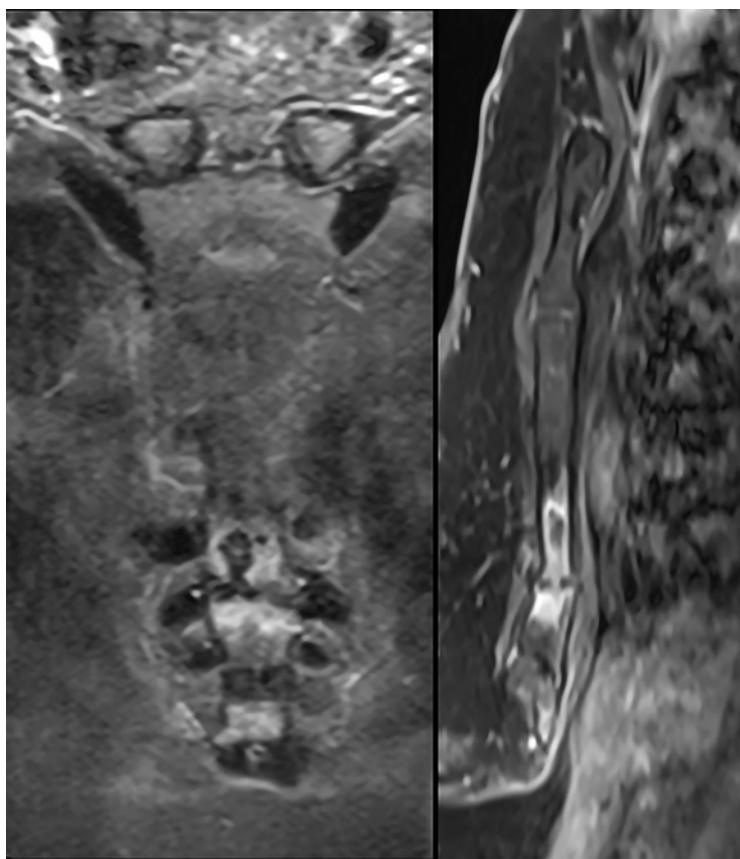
Coronal and sagittal MRI of the sternum documenting the extent of the lesion in 2020.
